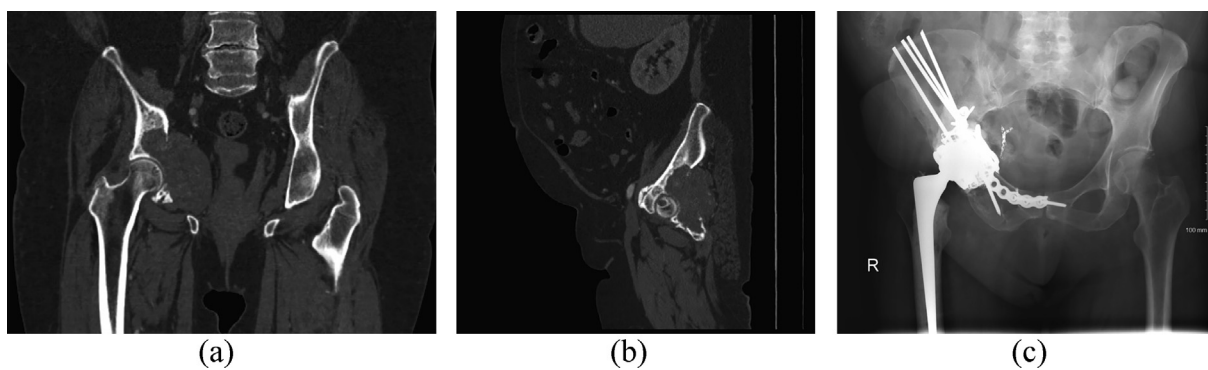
(a and b) Preoperative CT scan of a 77 year old female with metastatic adrenal cortical carcinoma (c) Postoperative radiograph following Harrington Plus Reconstruction.
